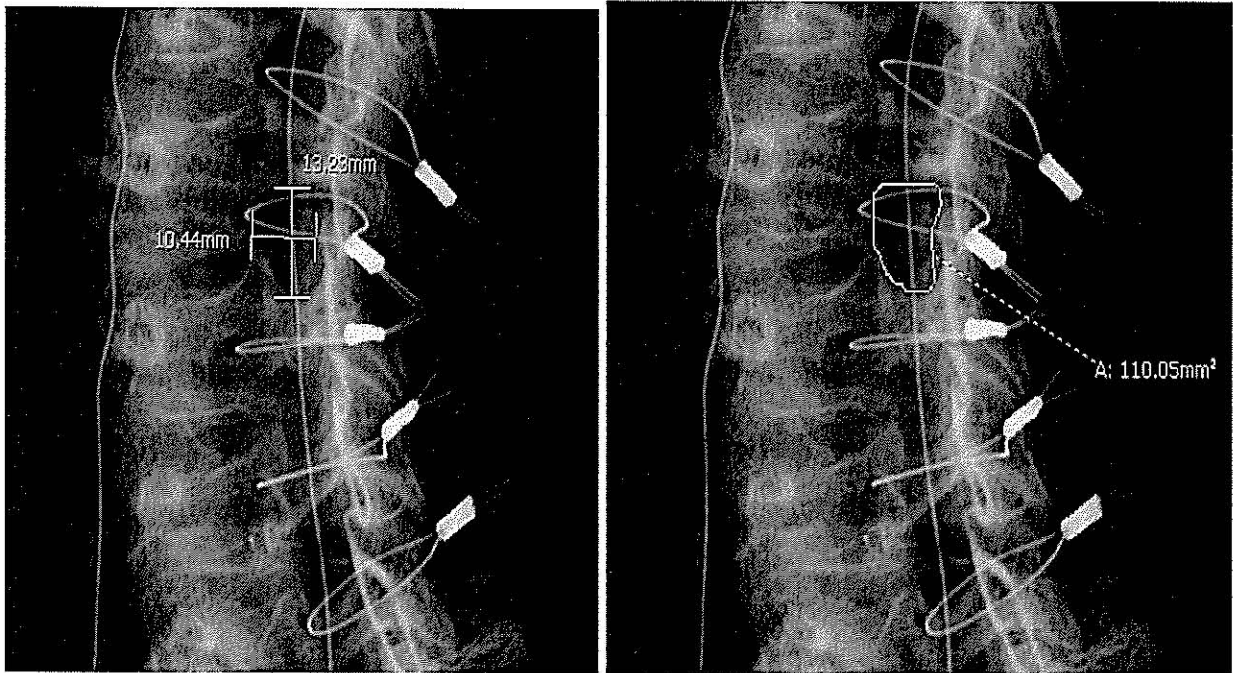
(left): Oblique radiograph with height and width measurements using Synapse.
